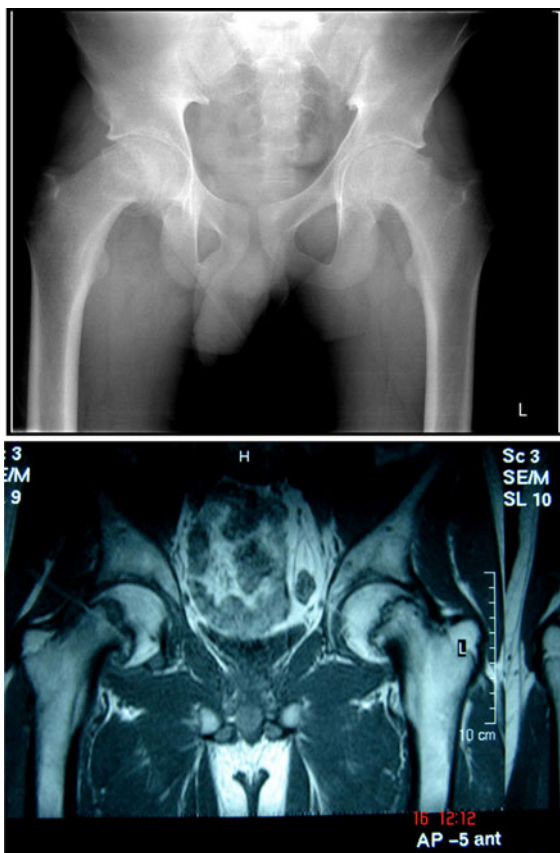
Plain X-ray and MRI scan of the patient pre-operatively showing AP view of bilateral SUFE
